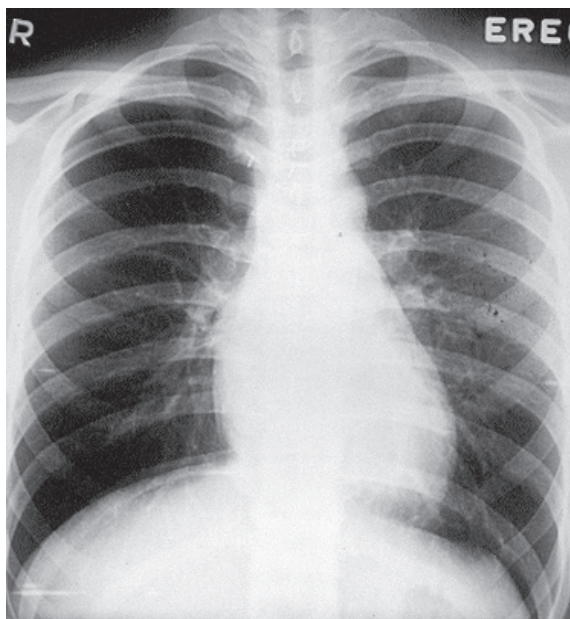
Chest radiograph post-surgical repair shows a normal heart size.
